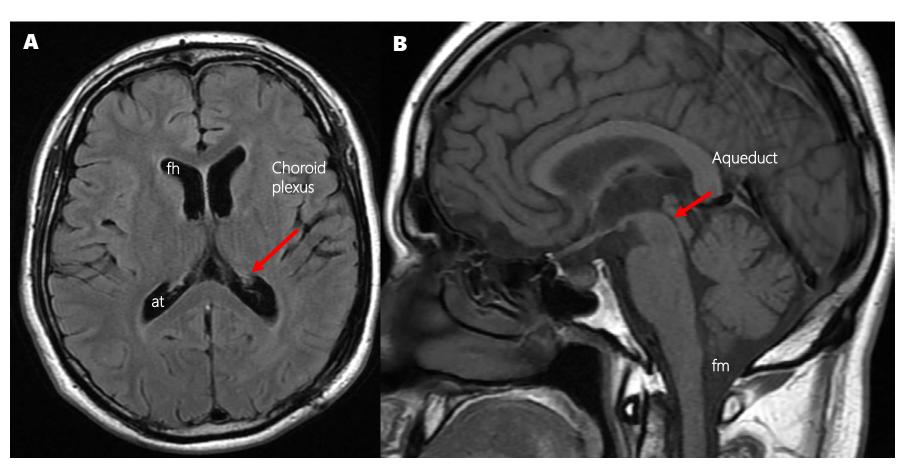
Anatomy of the ventricular system as seen on axial (A) and sagittal (B) MR images..
